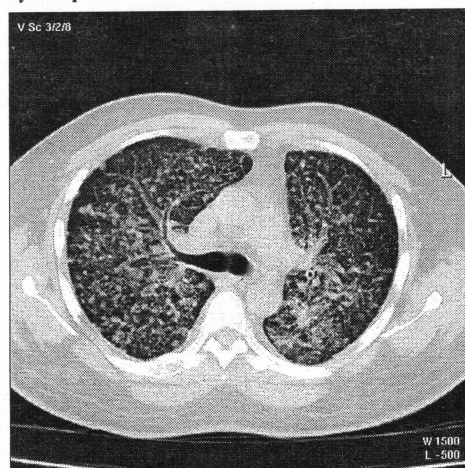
The same patient to Fig 1.2. Active PTB in bilateral lungs are demonstrated on chest CT
